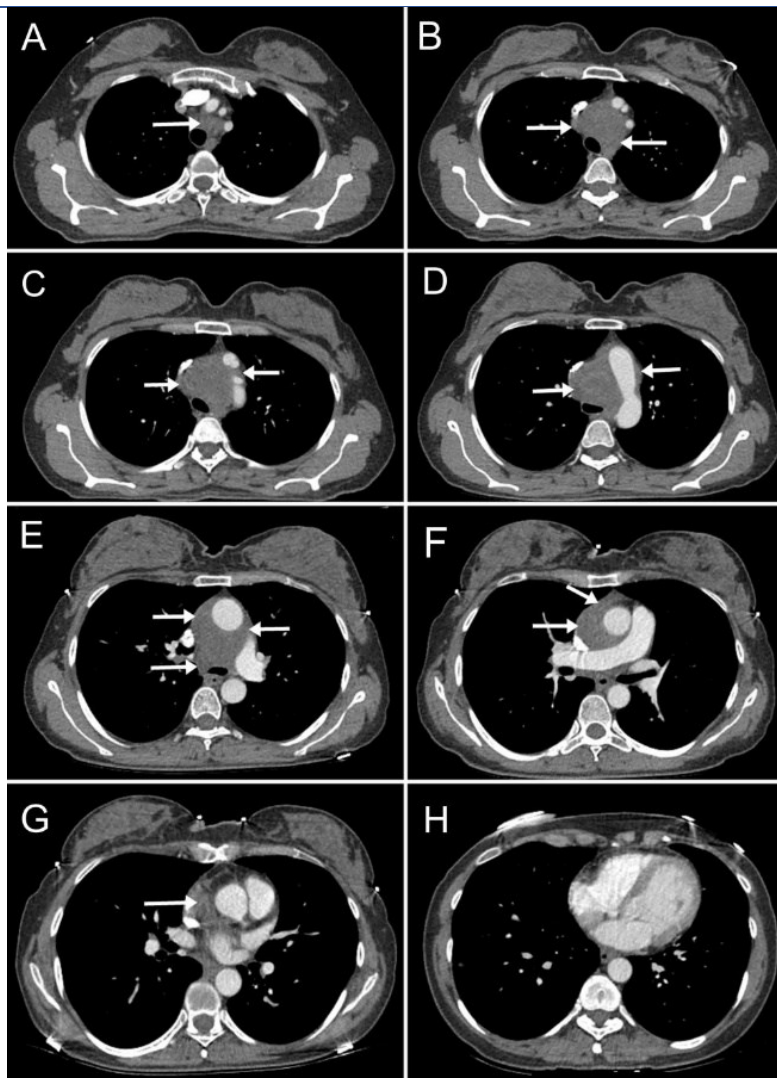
Axial contrast-enhanced thoracic CT images (A–H)
